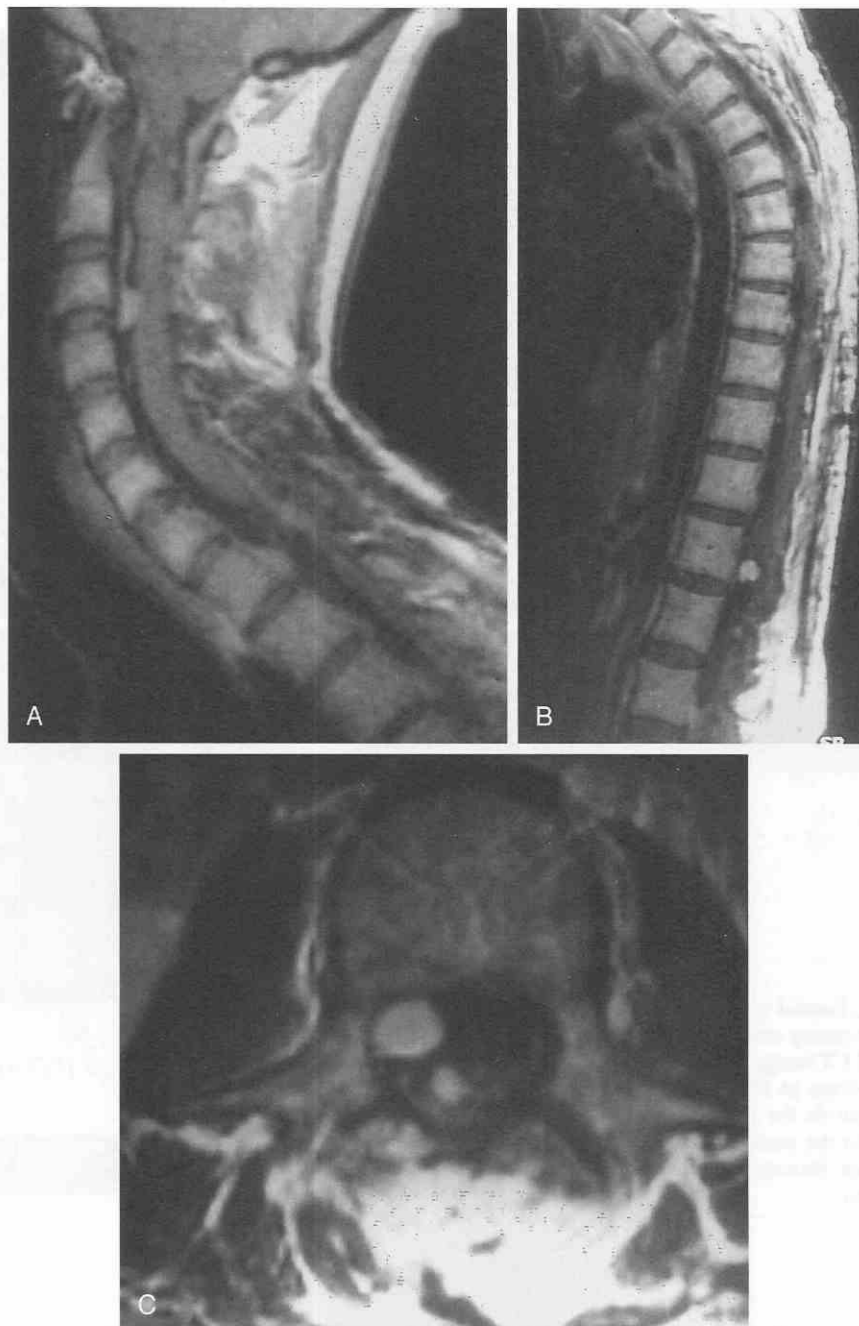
A, T1-weighted post-contrast-enhanced sagittal image of the cervical spine, demonstrating an enhancing extra-axial mass posterior to C2-C3 in a patient with known neurofibromatosis type 1. B, T1-weighted sagittal post-contrast-enhanced image through the thoracic spine, with enhancing neurofibromas in the lower thoracic spine. C, T1-weighted axial image showing extra-axial enhancing neurofibromas.
